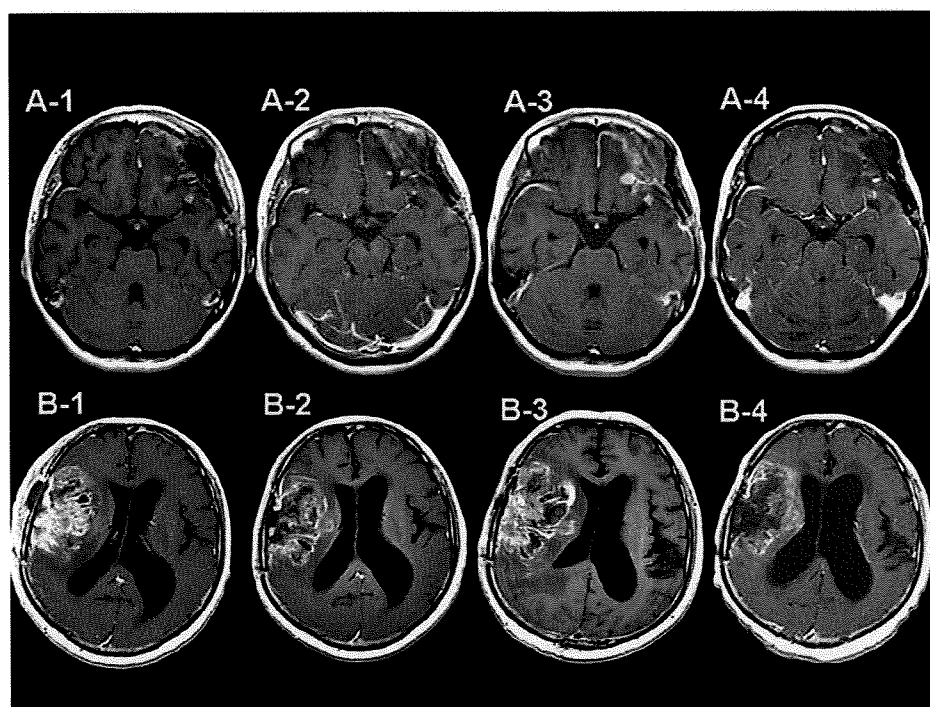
Two representative cases of pseudoprogression of recurrent malignant meningiomas treated by boron neutron capture therapy (BNCT). (A-1–A-4) Gadolinium (Gd)-enhanced MR images of case 50: prior to BNCT (A-1), 48 h after BNCT (A-2) 1 month after BNCT (A-3), and 2 months after BNCT (A-4). (B-1–B-4) Gd-enhanced MR images of case 56: prior to BNCT (B-1), 1.5 months after BNCT (B-2), 2.5 months after BNCT (B-3), and 6 months after BNCT (B-4).
